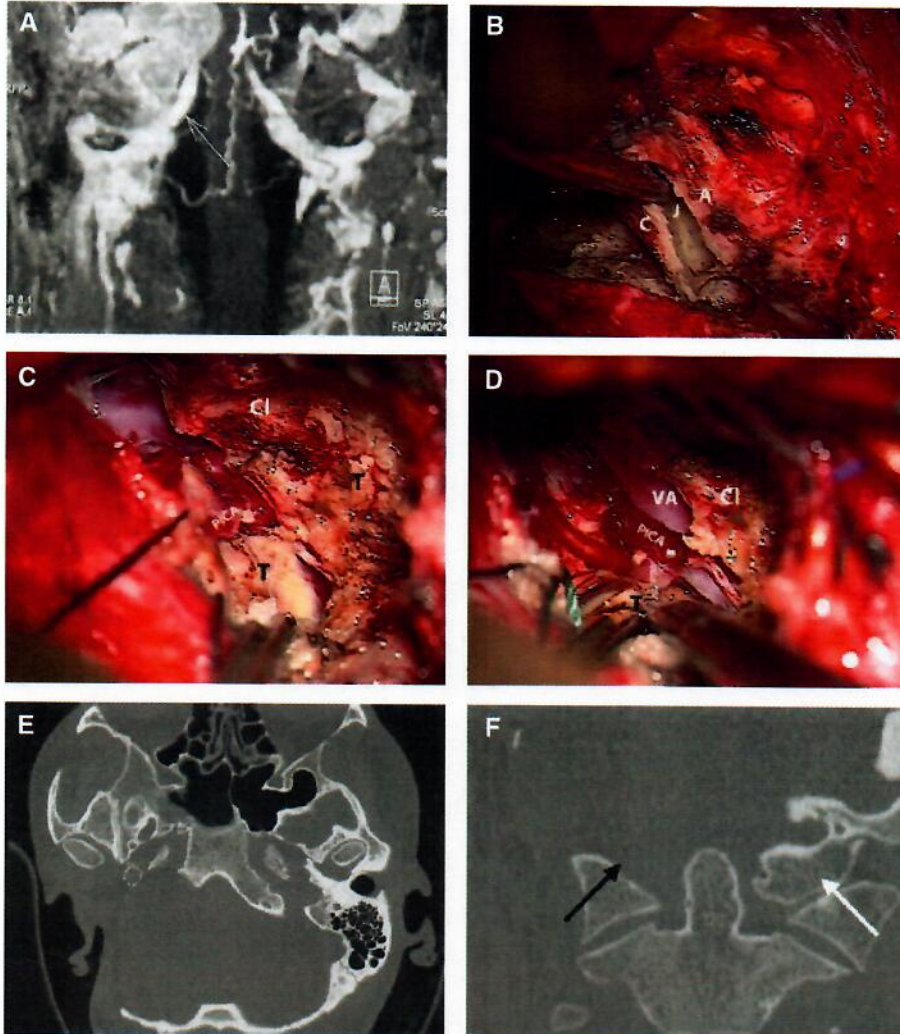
(A) A class C4Di2Vi tumor. MRI coronal image showing the tumor attached to the VA. (B–F) Surgical sequences of extreme lateral transcondylar approach. (B) The transverse process of the atlas (A) is drilled out and the atlanto-occipital joint (J) is removed. C = Condyle. (C) The tumor (T) is attached to the vertebral and posterior inferior cerebellar arteries infiltrating the clival (Cl) bone, which is partially drilled out. (D) The tumor is separated from the PICA. (E) CT scan. Axial view showing the stent in the ICA and the extent of bone removal. (F) CT scan coronal view showing the absence of the surgically removed occipital condyle (black arrow) compared to non-operated side (white arrow).
